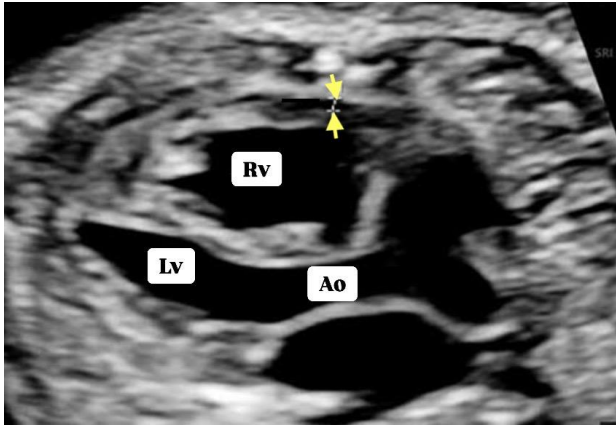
Sonographic imaging and measurement of epicardial fat thickness. LV: left ventricle; RV: right ventricle; Ao: aorta
